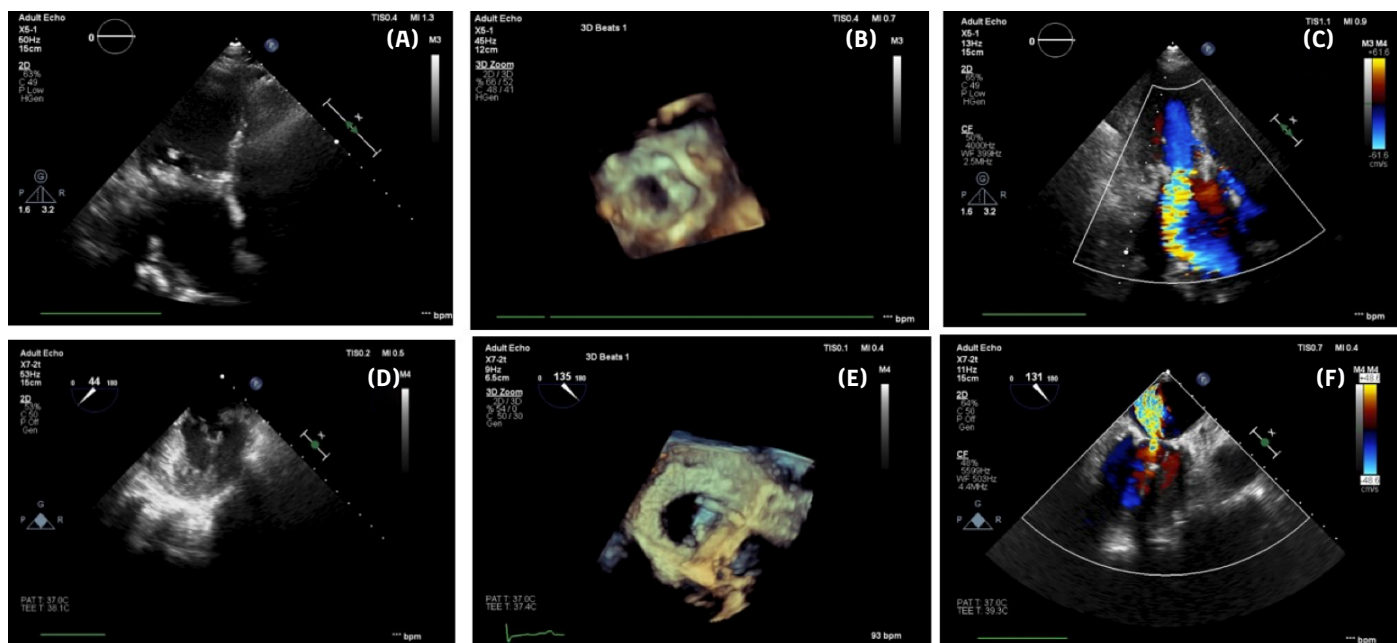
(A) Two-dimensional (2D) transthoracic echocardiography (TTE) image showing a calcific, degenerative mitral valve. (B) Three-dimensional (3D) TTE image showing severe circumferential calcification of the mitral valve. (C) Color Doppler TTE image showing severe mitral regurgitation. (D) Two-dimensional transesophageal echocardiography image showing calcific degenerative mitral valve disease. (E) Three-dimensional TEE image showing severe circumferential calcification of the mitral valve. (F) Two-dimensional TEE image showing severe mitral regurgitation.
